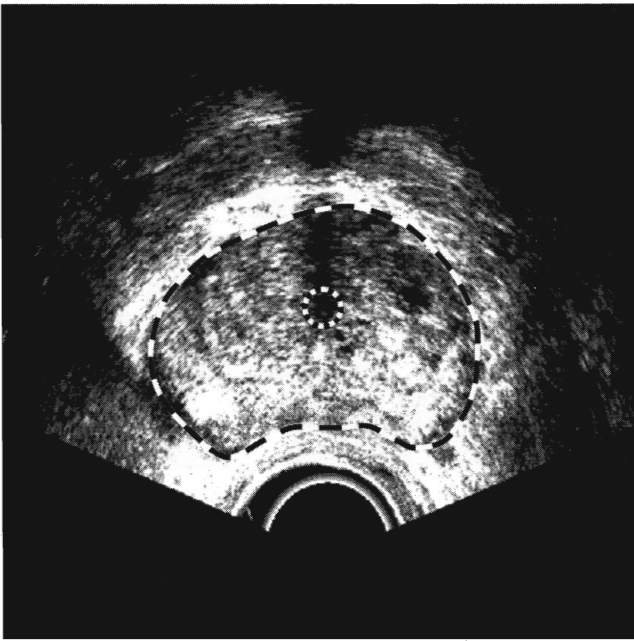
Ultrasound image of the prostate area. The outer contour of the prostate and the inner contour of the urethra are highlighted with dashed lines.
